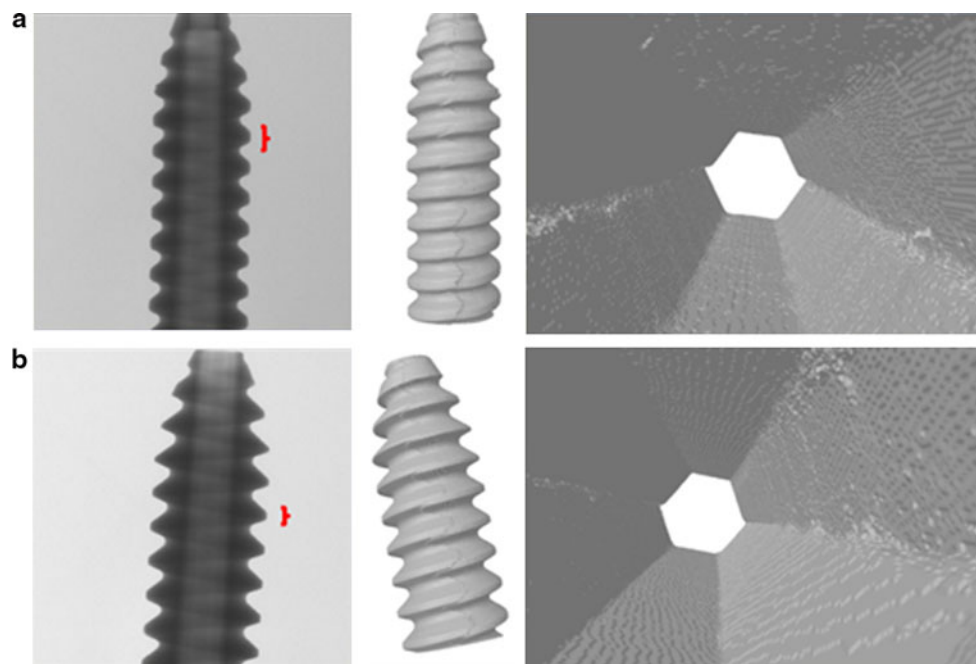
Micro-computed tomography 2D and 3D images of the PLLA screws (Arthrex, Naples, FL, USA): a implanted screw, and b non-implanted screw. No major structural differences occurred. The most
